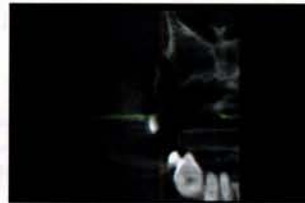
CBCT imaging (Green PaX-i3D [Vatech America]) was utilized to visualize the bone. Note that the bone, in preparation for an immediate implant placement, was intact and not damaged during the Physics Forceps extraction.
